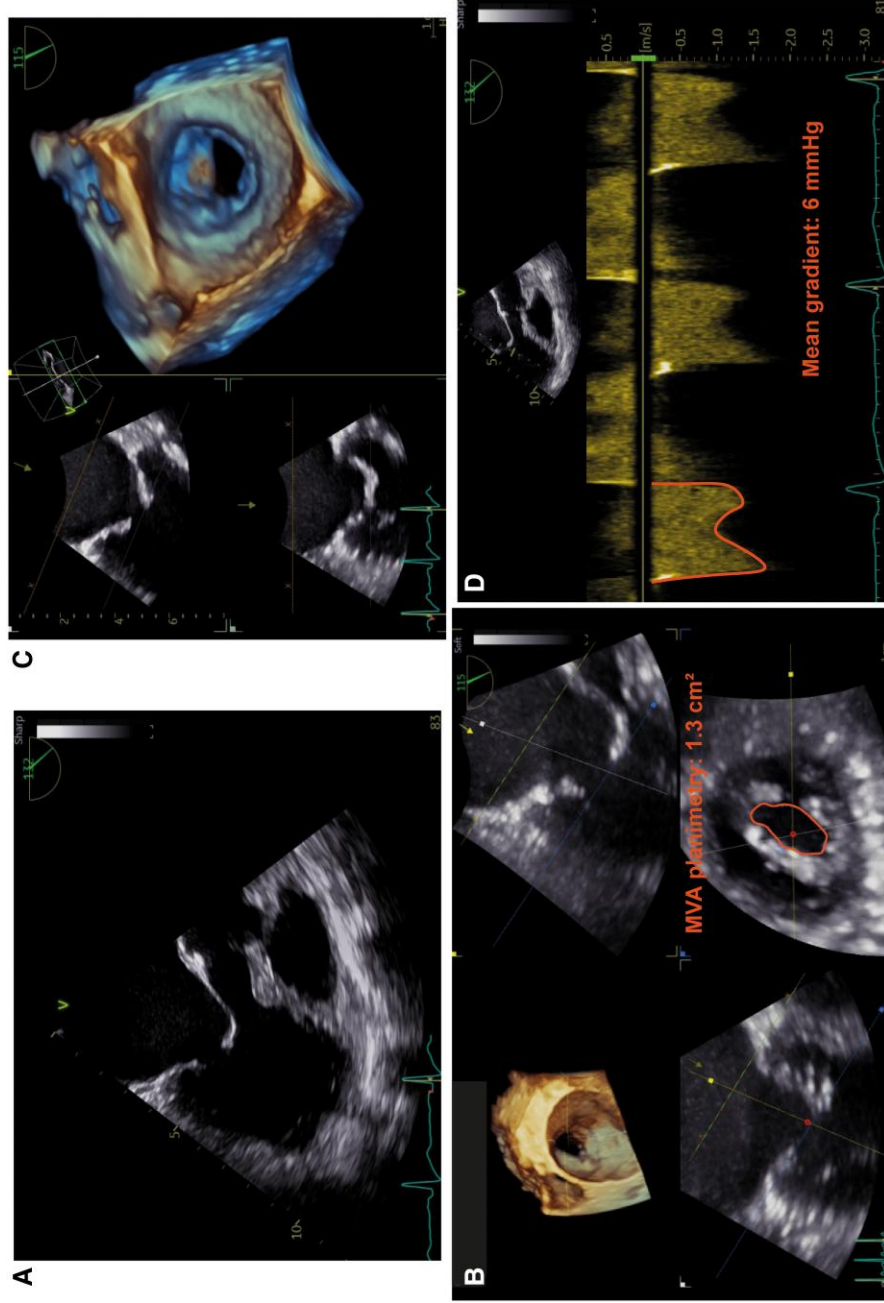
Rheumatic mitral stenosis (MS) in a 52-year-old woman. Rheumatic MS is more commonly observed in women. In this case, 3D transesophageal echocardiography (panels A and C) demonstrated commissural fusion and diastolic doming of the anterior leaflet, with a markedly reduced mitral valve area (1.3 cm²), despite mean transmitral gradients in the non-severe range (6 mmHg; panel D). This pattern is frequently encountered in women, who often present with reduced anterograde flow and lower transmitral gradients. MVA, Mitral valve area (measured by planimetry).
